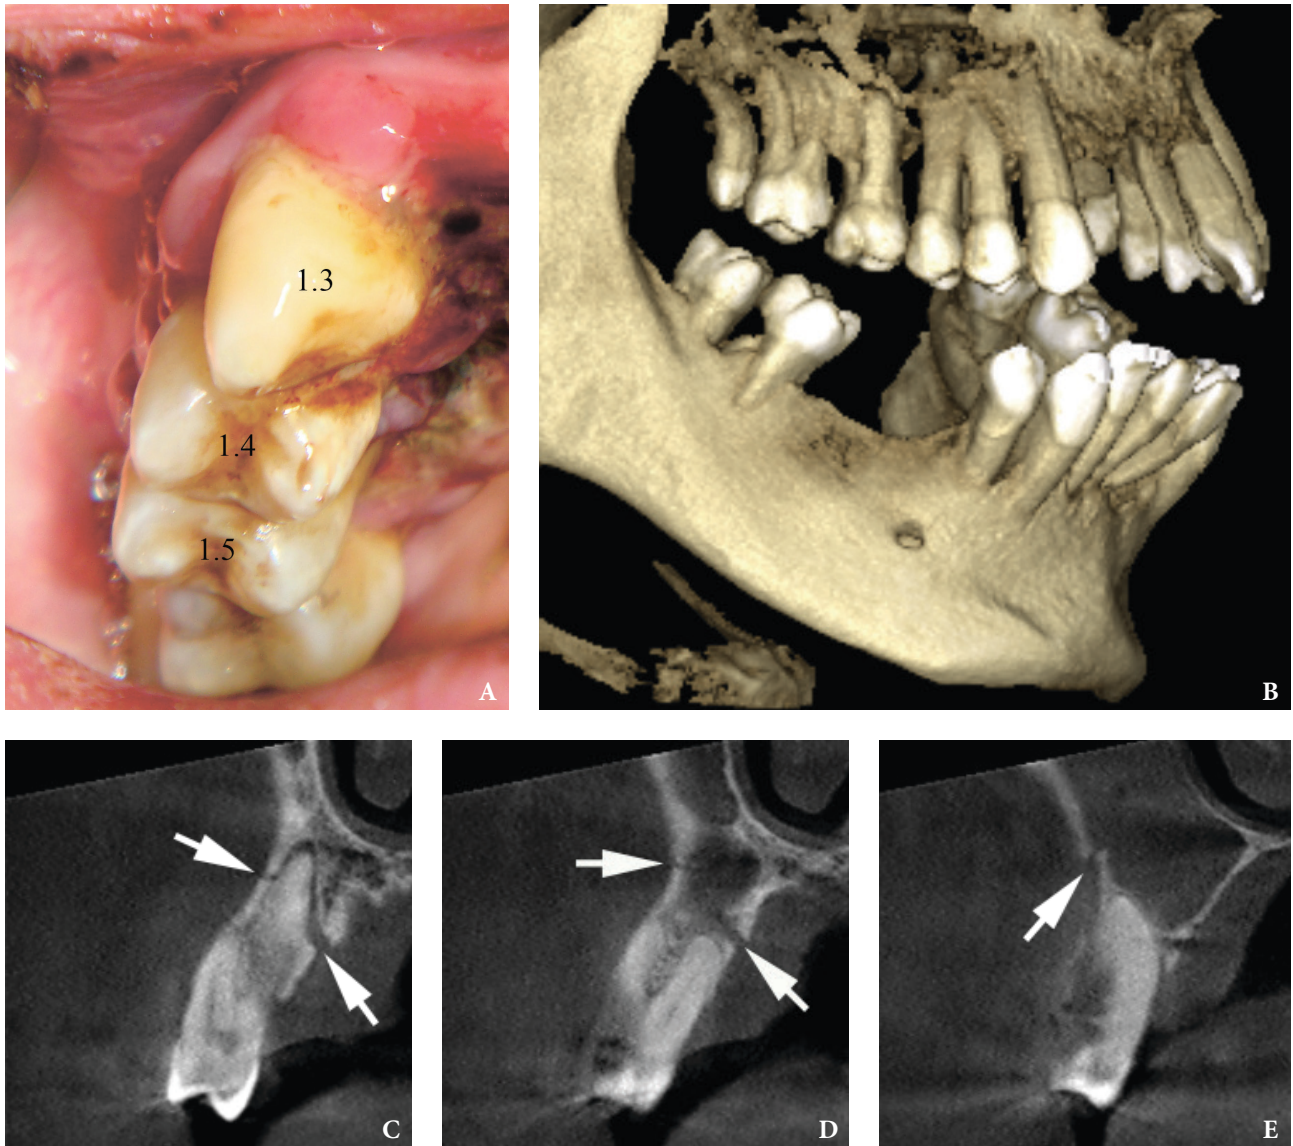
A 45-year-old Caucasian male after the injury. Intraoral view (A) shows mucosal laceration and buccal dislocation of the teeth 1.5, 1.4, and 1.3. Cone-beam computed tomography (3-dimensional [B] and coronal scans [C-E]) shows segmental alveolar fracture (arrows) at the right maxilla with dislocation of involved teeth 1.5–1.3. Image C demonstrates tooth 1.3 and fracture line/gap located coronal to apical foramen. Image D visualizes tooth 1.4 and fracture line located apical to apical foramen. Image E shows tooth 1.5 and fracture line located apical to apical foramen. Printed with permission and copyrights retained by I.I.F.
